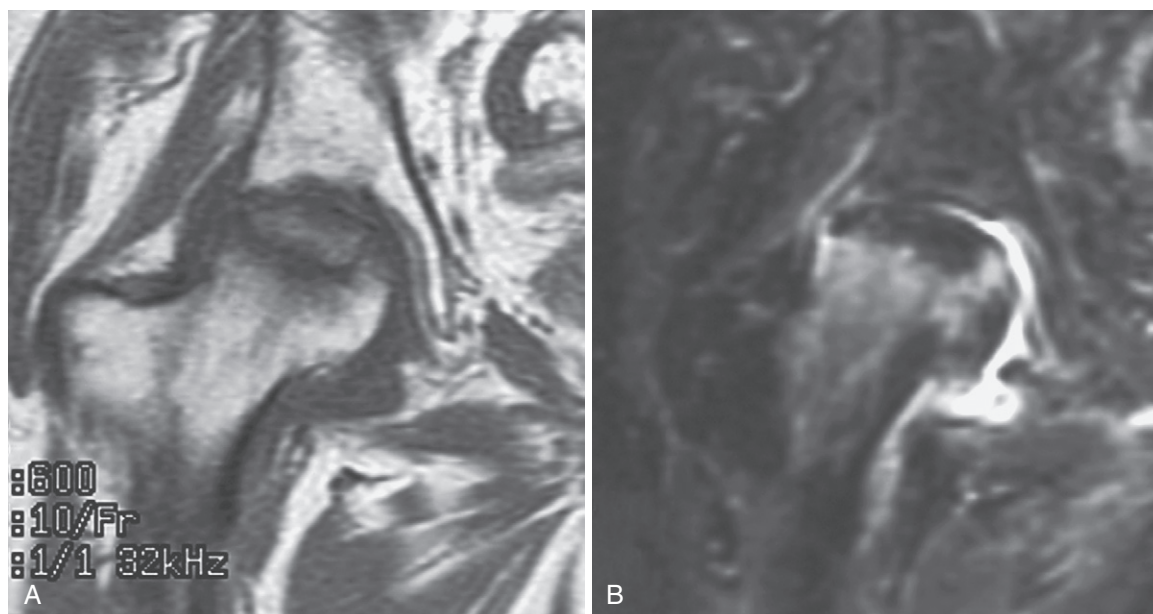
Advanced osteonecrosis of the right femoral head exhibits low signal intensity on T1-weighted (A) and T2-weighted (B) MR images.
